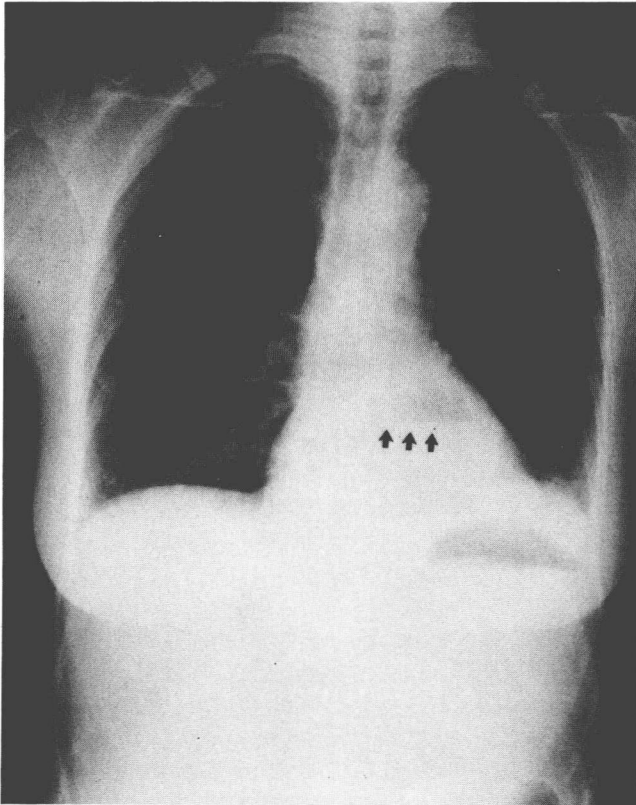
Repeat posteroanterior and lateral chest radiograph, 90 minutes after presentation. Note air-fluid level in mediastinum (arrows). (Courtesy of Micon L, Geis L, Siderys H, et al: *J Trauma* 30:214–217, 1990.)
